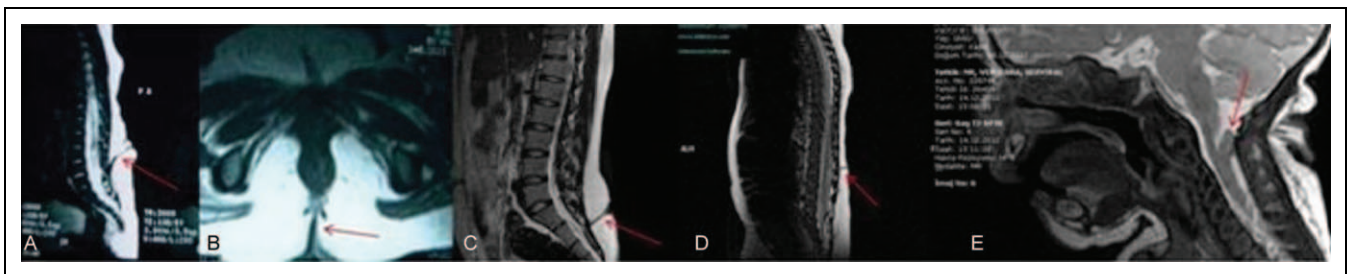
Sagittal and axial lumbar magnetic resonance images (MRIs) demonstrated (red arrow) an apparent lateral sinus tract originating from the midline skin surface and extending down to the spinal canal (A-D). The red arrow (E) shows a cervical myelomeningocele in which we noted dermal sinus tract during surgery that was attached to the spinal cord.
